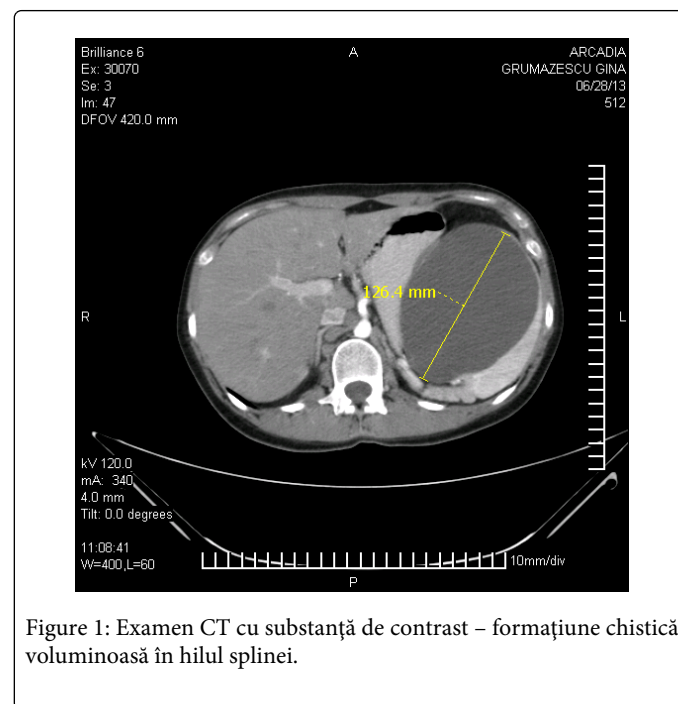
Examen CT cu substanță de contrast – formațiune chistică voluminoasă în hilul splinei.
